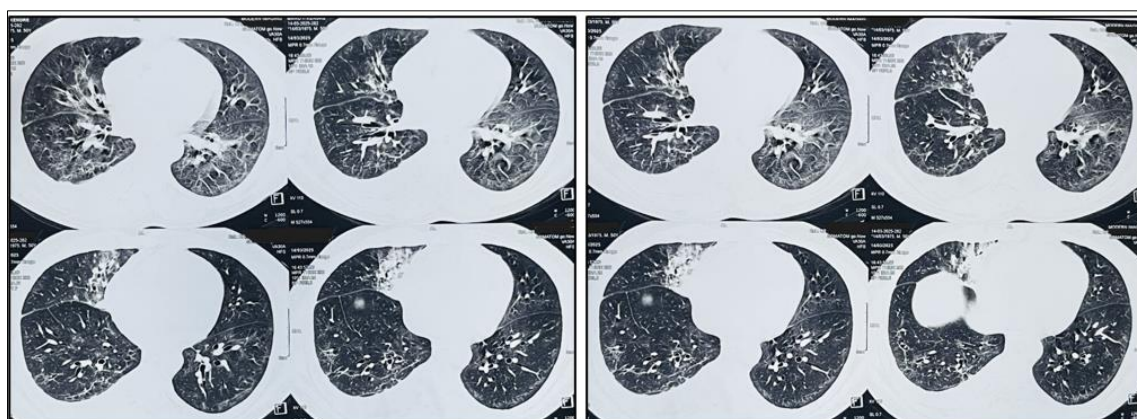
HRCT imaging's showing nodular infiltrates in right middle lobe and lower lobe with pleural effusion right side
